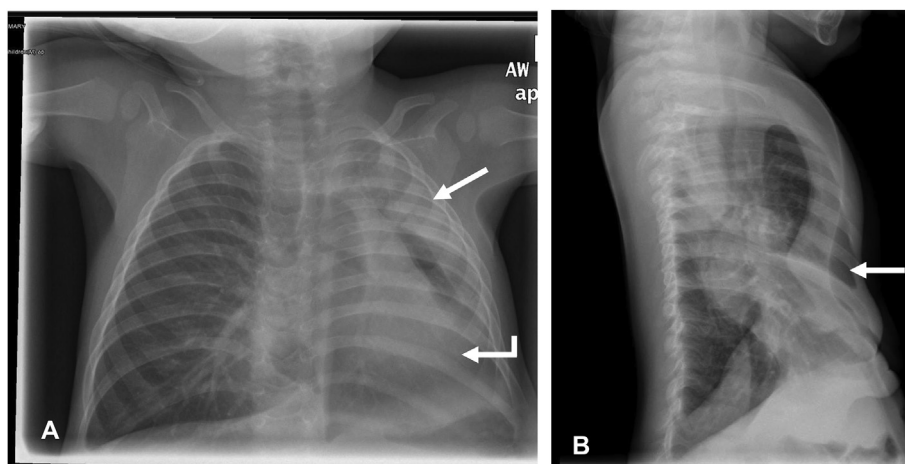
Frontal chest radiograph at 1 year of age demonstrates collapse of the left upper lobe and lingula (straight arrow, A). Marked leftward mediastinal shift (angled arrow, A) is caused by a severe pectus excavatum deformity, as shown on the lateral image (arrow, B).
